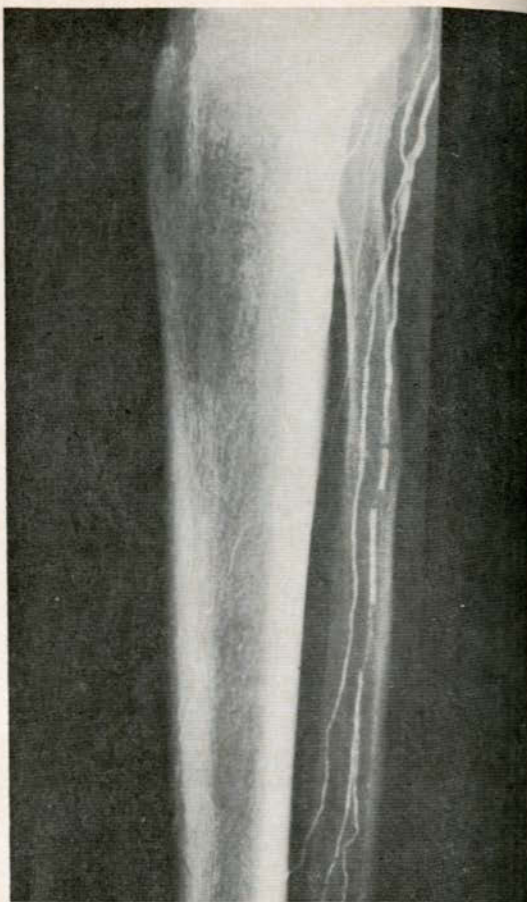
X-ray of leg following injection of radio-opaque dye into a lymph channel in the foot. Such monitoring films must always precede administration of radioactive gold.
